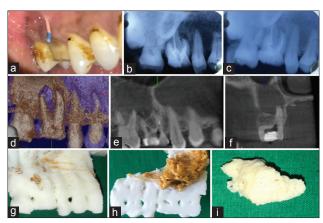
(a) – Clinically sinus tracing, (b) – radiograph of sinus tracing, (c) – obturation with 16, (d and e) – sagittal view of cone-beam computed tomography, (f) – coronal view of cone-beam computed tomography, (g) – three-dimensional full model, (h) – cross section of three-dimensional model, (i) – three-dimensional view of lesion
